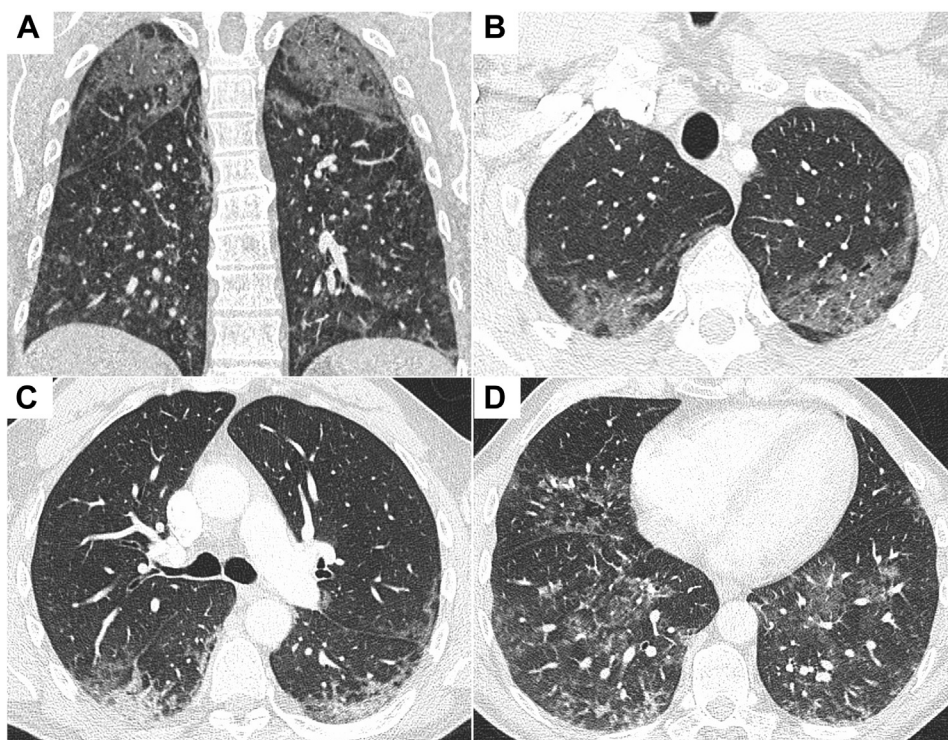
A-D, CT pulmonary angiograms demonstrating diffuse bilateral ground-glass change with reticular nodular opacification in the lower lobes: coronal image (A) and axial slices from lung apices to bases (B-D).
